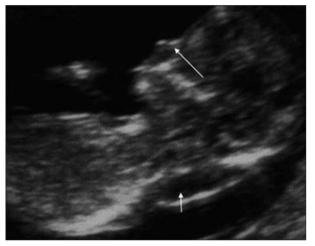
Ultrasound image of a 12-week trisomy 21 fetus with increased nuchal translucency thickness (*short arrow*) and an absent nasal bone (*long arrow*).
